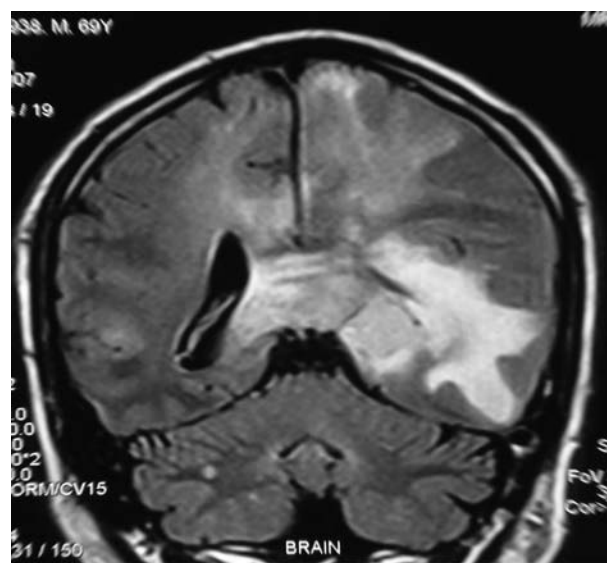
Follow-up MRI. Coronal MRI done 3 months later revealed increase in the size of lesion with mass effect in temporal lobe.
